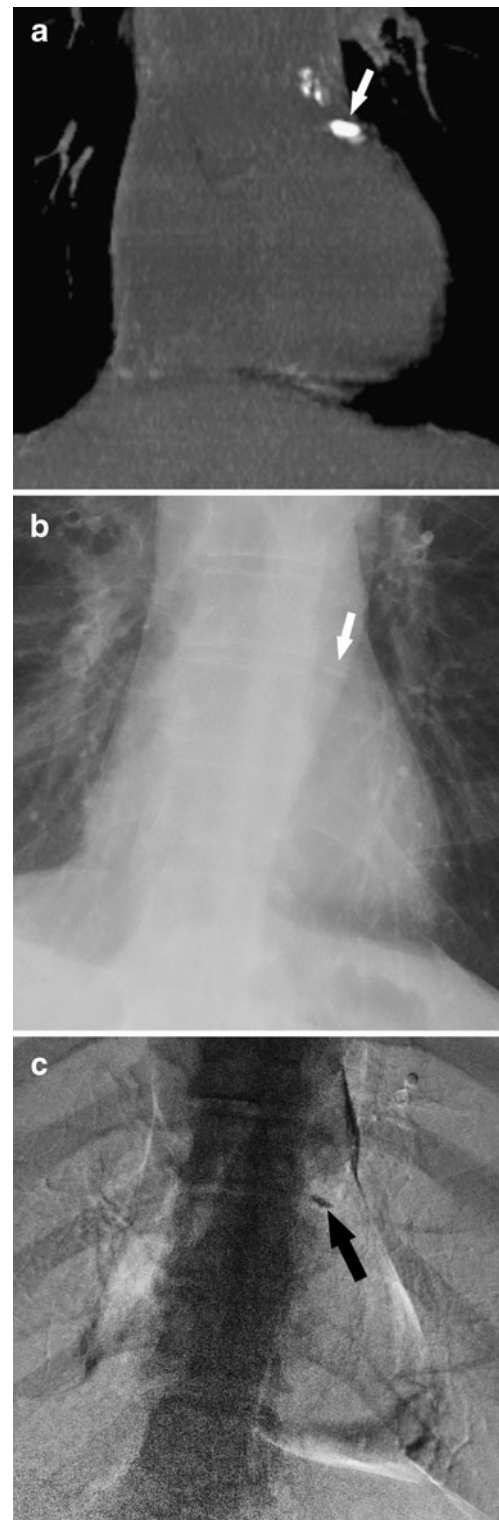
Detection of CAC by CT and DE: a CT coronal reconstruction of CAC in the proximal LAD (*white arrow*). b Corresponding standard PA radiograph suspicious for CAC (*white arrow*). c Corresponding DE image demonstrating calcification in the region of the LAD (*black arrow*)
